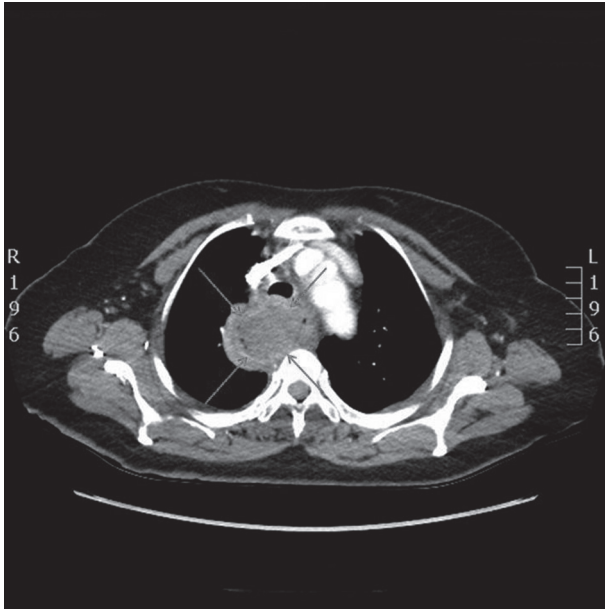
CT scan of the thorax showing a multinodular stenosing mass (10cm x 5cm) in the mid-esophagus with some calcifications in the border of the mass (arrows). The mass caused deviation of the trachea and narrowing of the main bronchi.
